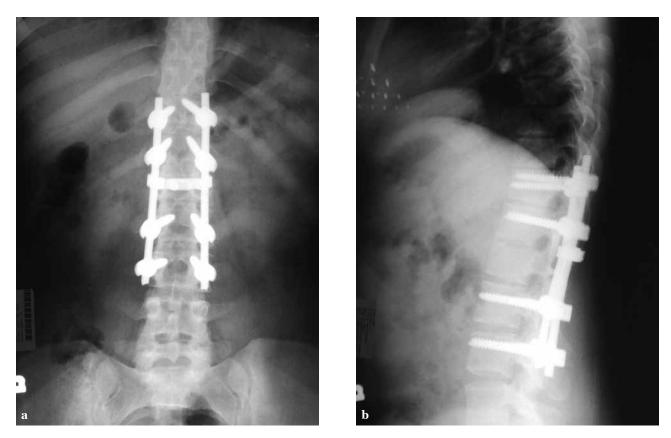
20-year-old female treated with long segment instrumentation : (a) anteroposterior and (b) lateral radiographs at 30 months follow-up.
